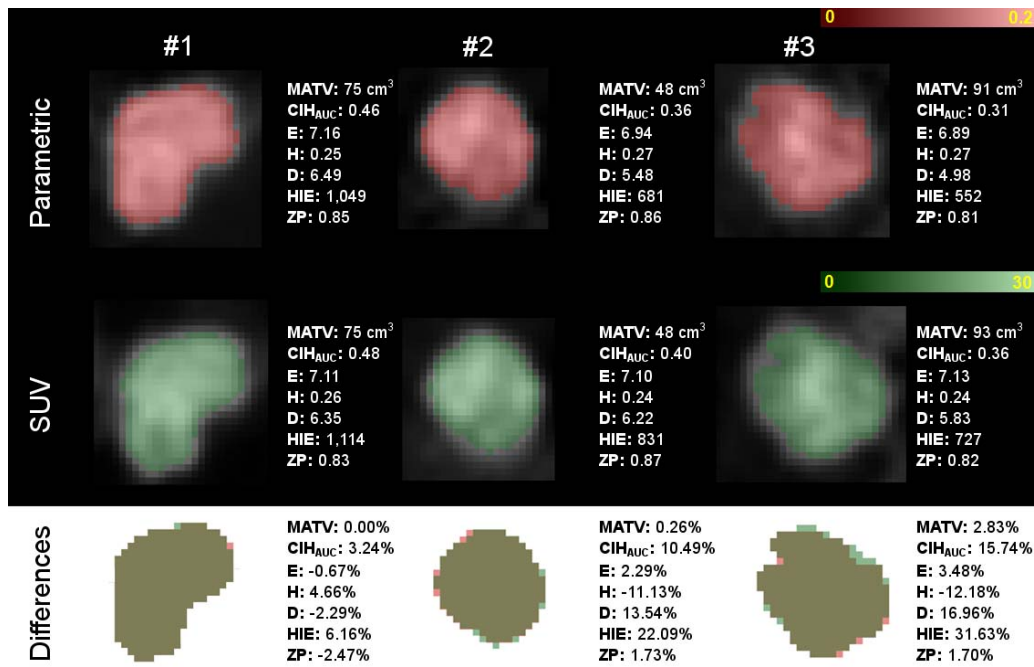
Three different tumor examples with parametric Ki and SUV images in the upper and middle row respectively and differences between the two images in the bottom row. Examples 1, 2 and 3 correspond to cases with small, medium and large differences between parametric Ki and static SUV images respectively.
